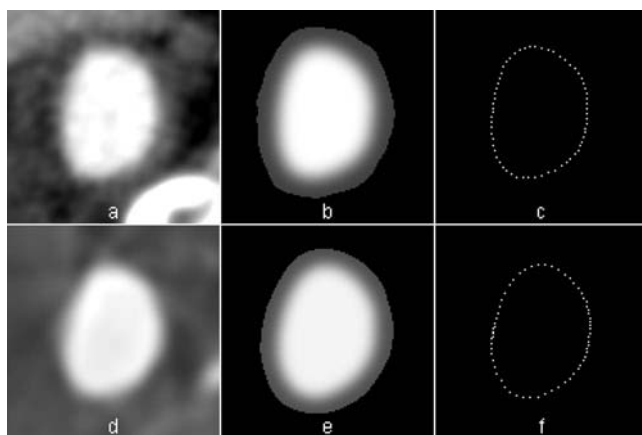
Cross-sections of the common carotid artery of patient 1, second image of the proximal section (Fig. 9, at 0.5 mm). (a) shows the CTA image and (d) the 3DRA image. The other figures show the fitted model images (middle column) and contours (last column) for CTA (upper) and 3DRA (lower) using four Fourier terms. The contours bound the (unblurred) shapes. Each image measures $12.8 \times 12.8 \text{ mm}^2$. The window center is 160 HU and the window width is 400 HU for images (a) and (b); the window width and level in the images (d) and (e) were chosen to obtain approximately the same gray values for the artery and background.
